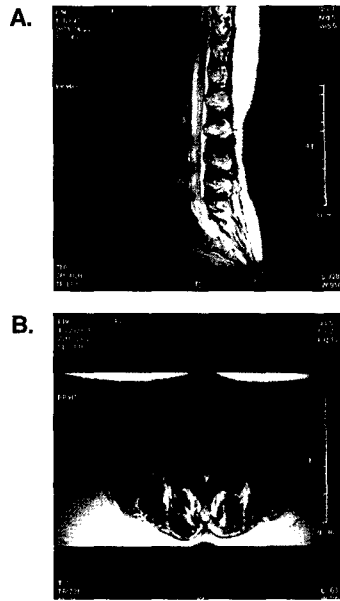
MRI of lumbar spine, performed 28th Apr., 2001.
